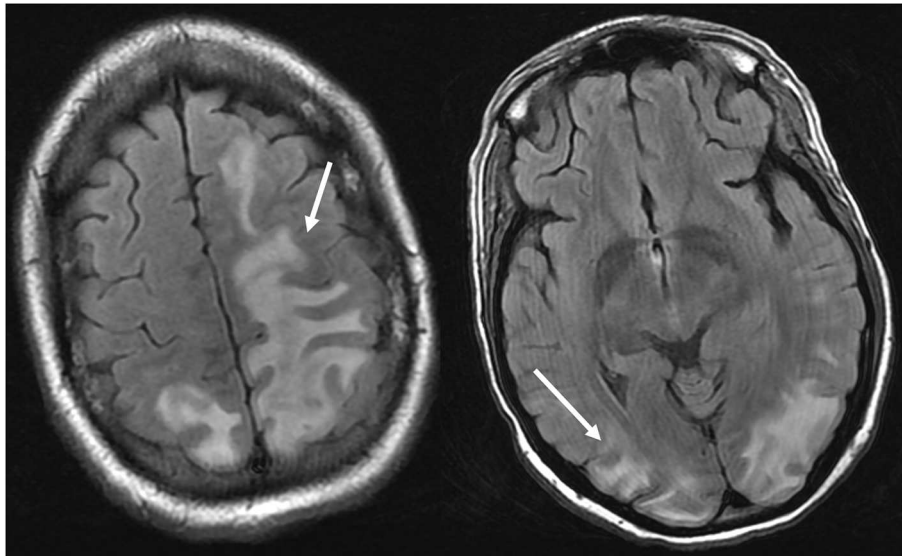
Patient with systemic lupus erythematosus and rapidly progressive glomerulonephritis presenting with seizure. T2-FLAIR images of the head demonstrates vasogenic edema in the bilateral parietal and occipital lobes, left greater than right, as well as extension into the left frontal lobe. Note that with the vasogenic pattern of edema, there is sparing of signal abnormality in the cortex.
